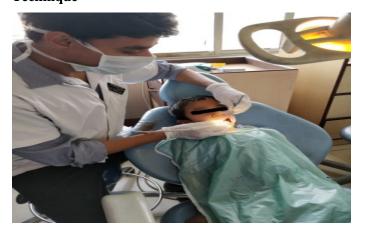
ultrasonic Scaling was performed after behavior modification by Tell-show-Do technique
